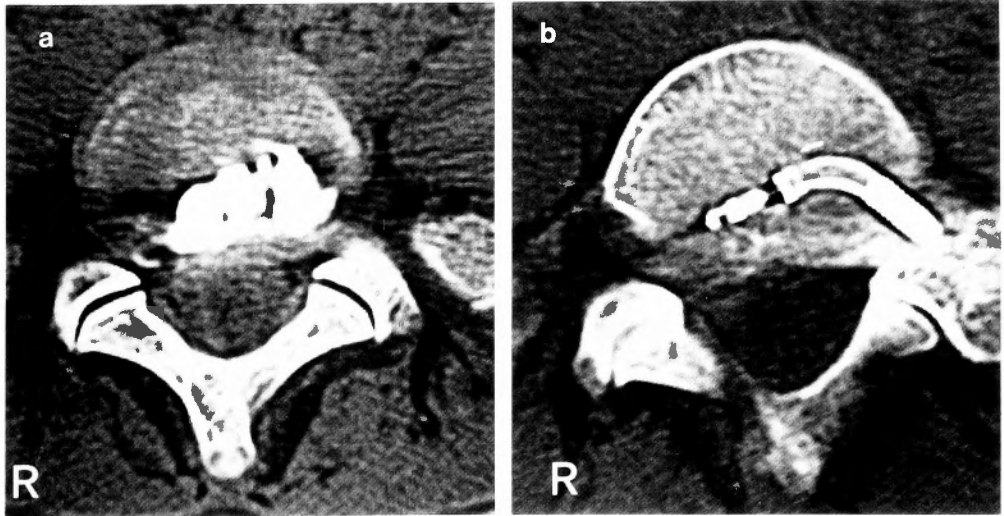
b a; Preoperative CTD of Case 2. A 17-year-old man reported back and right lower leg pain. Conservative therapy before percutaneous discectomy was followed for 2 months. CTD showed disc protrusion with broad dye base at L5-S1. b; Intraoperative CT of Case 2. The tip of the nucleotome flexes posteriorly to resect the area near the herniation. By comparing the preoperative CTD (Fig. 1-a), it was confirmed that the nucleotome flexed within the area where the dye had spread.
